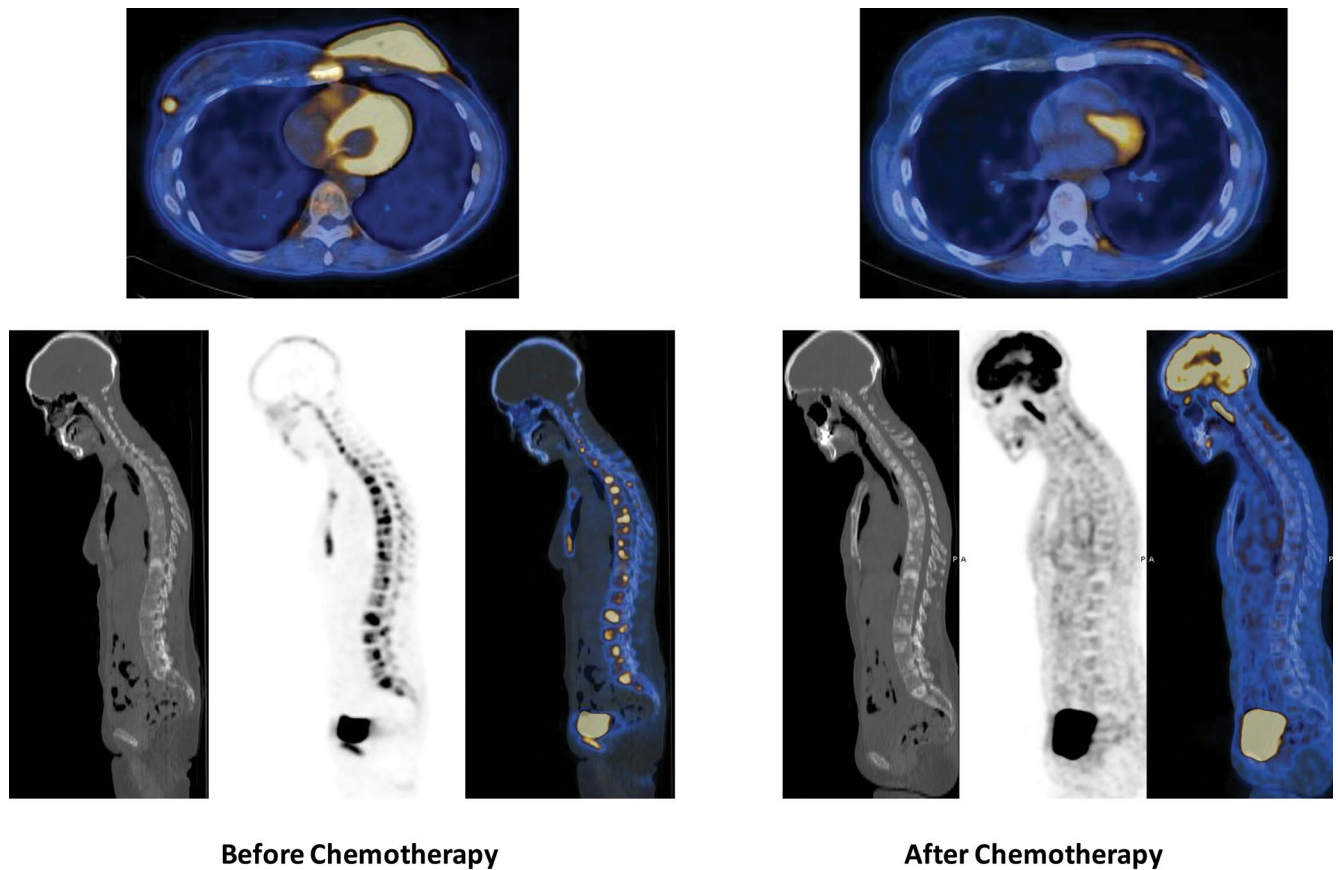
FDG PET/CT images on hormone therapy with an aromatase inhibitor (before chemotherapy) and after treatment with a combination of aromatase inhibitor and chemotherapy (targeted therapy with an inhibitor of the cyclin-dependent kinases CDK4 and CDK6) (after chemotherapy) in a 41-year-old female with inflammatory breast cancer. PET images before chemotherapy show diffuse infiltration of the left breast with markedly increased metabolic activity and multiple lytic and hypermetabolic bone metastases. Note also a hypermetabolic focus in the right breast laterally. Following chemotherapy, there is a resolution of the primary tumour on both PET and CT images with only mild diffuse chest wall activity which is probably due to inflammatory changes although residual tumour cannot be excluded. There is also the resolution of hypermetabolic bone metastases and most of the lytic bone lesions become sclerotic after the treatment
